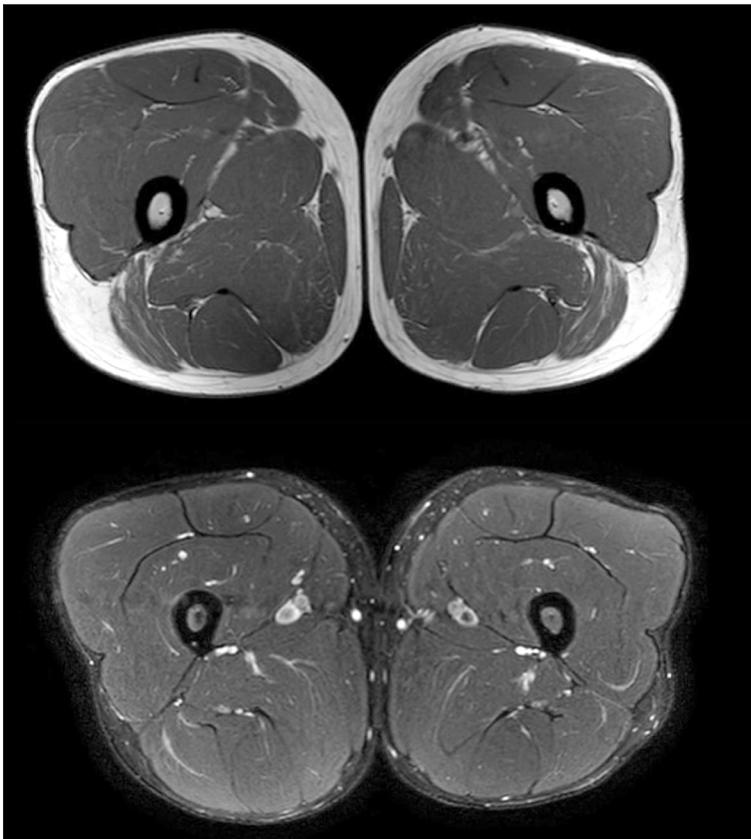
MRI of the bilateral thighs. All muscles and intermuscular fascia showed no evidence of edema or an inflammatory myopathy.
